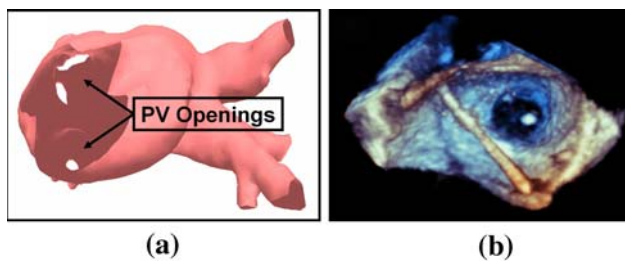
3D Visualization. In a we see a surface mesh of the left atrium, segmented from a cardiac CT scan. The mesh provides a gross anatomic view of the entire left atrium, while still retaining high-resolution detail of smaller features such as the pulmonary vein (PV) openings (*white circles*). In b we see a 3D ultrasound image taken of a PV opening (*dark circle*) and ablation catheter (*line pointed down*). While 3D ultrasound is updated in real-time, it can only image a small volume of space
